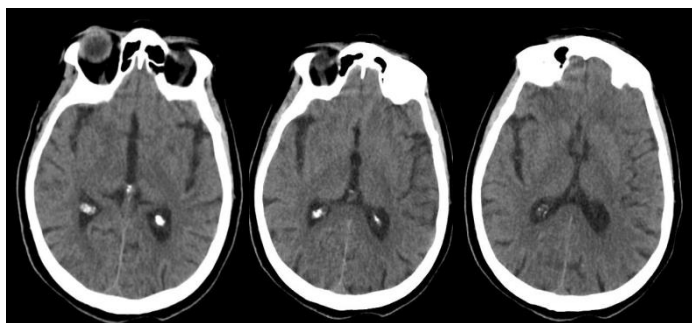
Brain computed tomography was normal.
